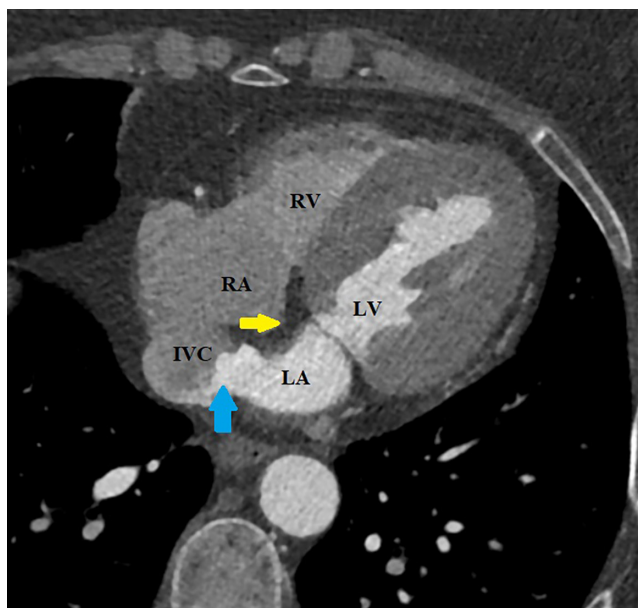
Computed tomography angiography image. The blue arrow indicates the echo interruption in the wall of the IVC, and the yellow arrow indicates the atrial septum. IVC, inferior vena cava; LA, left atrium; LV, left ventricle; RA, right atrium; RV, right ventricle.
